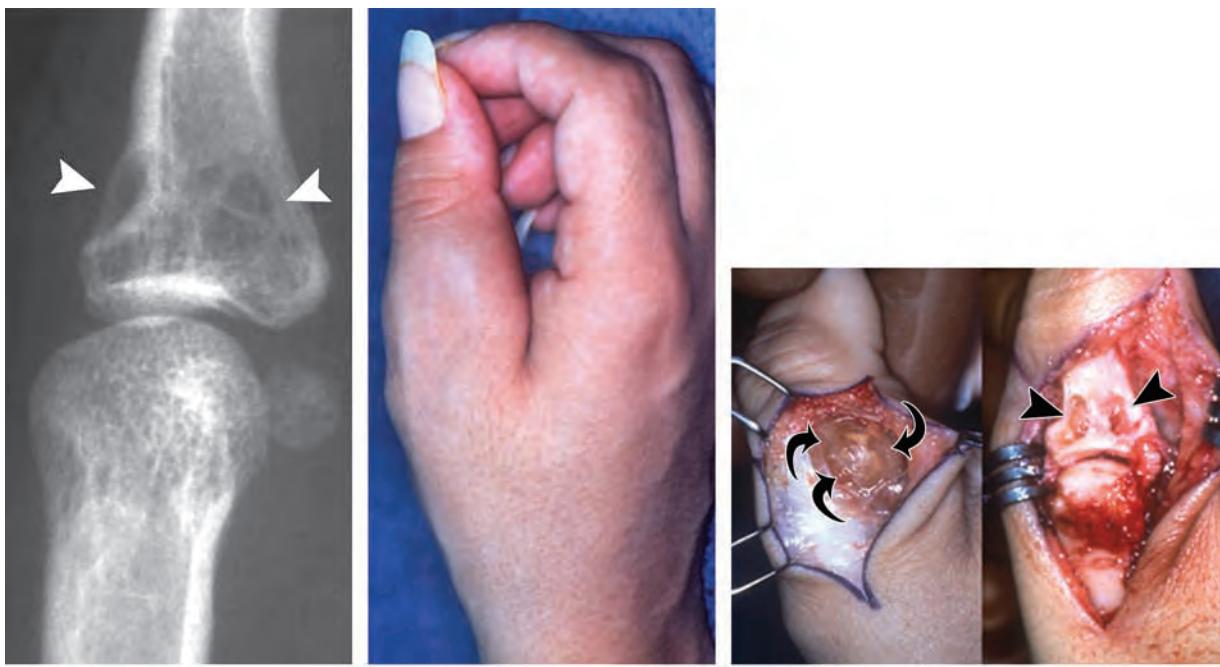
Localized extraarticular PVNTS involving the thumb in a 26-year-old woman with a palpable, slowly enlarging, soft-tissue mass. (a) Oblique radiograph of the thumb shows soft-tissue swelling and well-defined areas of subchondral lysis with sclerotic margins that represent bone erosions (arrowheads). (b) Clinical photograph reveals soft-tissue swelling and a soft-tissue mass involving the thumb. (c) Intraoperative photographs demonstrate the nodular brownish soft-tissue mass (curved arrows) and, following lesion resection, extrinsic erosion of the proximal phalanx (arrowheads). The erosion corresponds to that seen on the radiograph (a).
